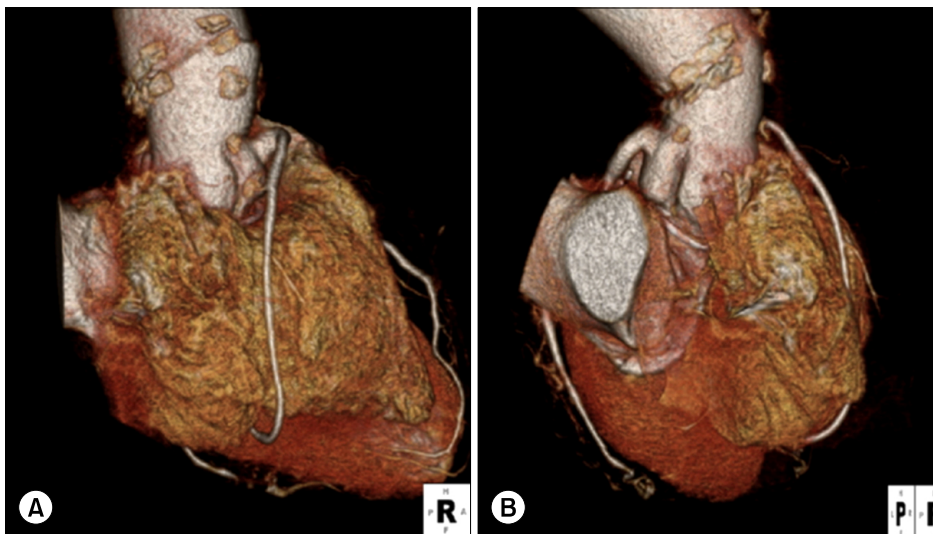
(A, B) Postoperative computed tomographic images (3-dimensional reconstruction) show reconstructed neo-sinuses, interleaflet triangles, and patent coronary artery button anastomoses.
